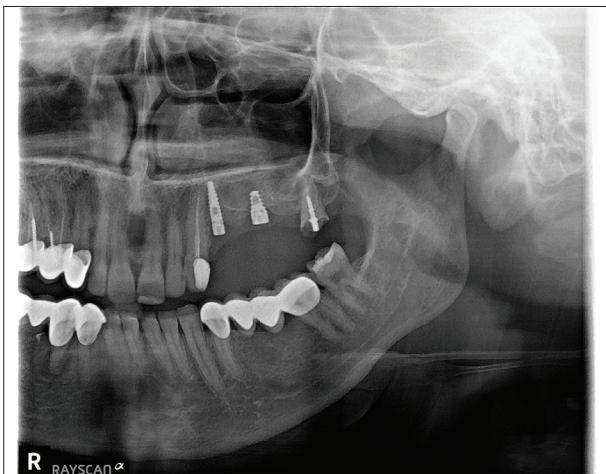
Follow-up panoramic X-ray after six months
